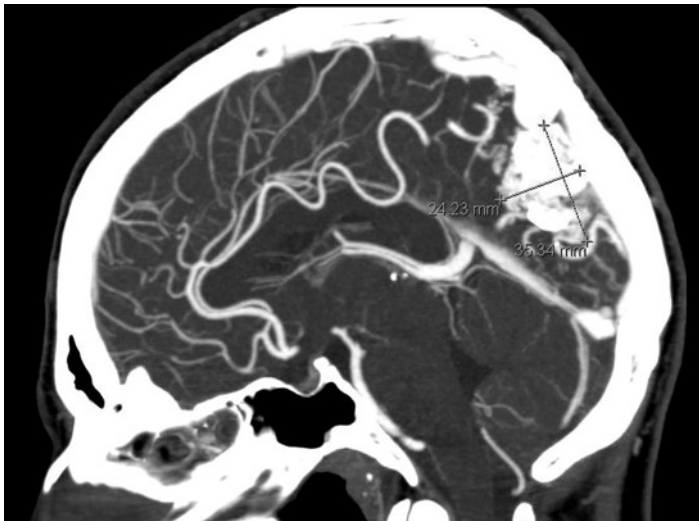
CT angiography of the head, sagittal cut, of 26 year old G4P2012 woman. Note presence of left posterior parietal AVM with prior stage 2 embolization.
